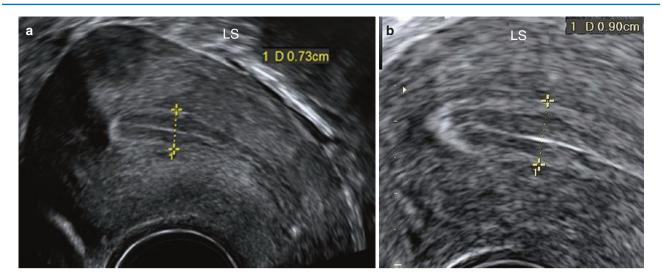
(a, b) Endometrium is measured in the midsagittal section of the uterus perpendicular to the endometrial midline, excluding the hypoechoic adjoining myometrium. The measurement is most accurate when the ultrasound beam is perpendicular to the endometrial stripe
